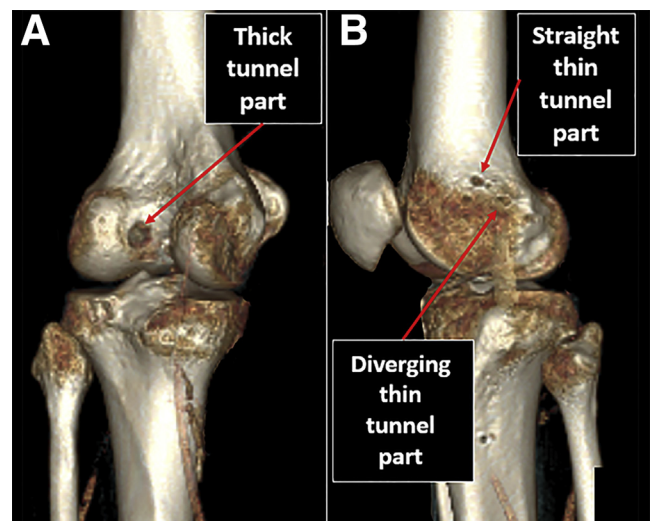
Postoperative computed tomography images indicating the orifice of the thick femoral tunnel part (A, posterior medial view of left knee) and the orifices of the straight and diverging thin tunnel parts (B, lateral view of the right knee).
